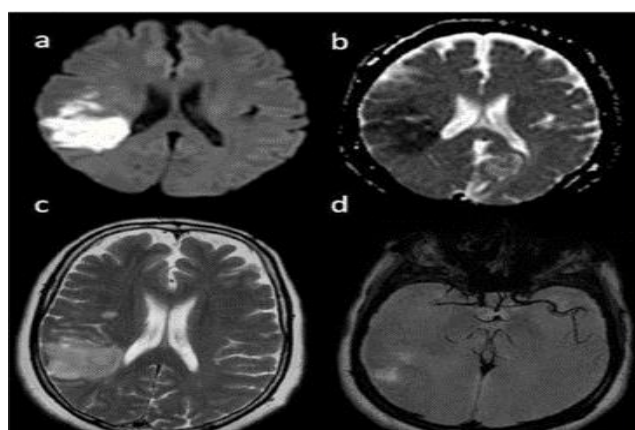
(A-D): Some of the brain advanced sequences: Diffusion-weighted imaging (DWI), apparent diffusion coefficient (ADC) map, T2 weight image, and dark blood magnetic resonance angiography (MRA).
